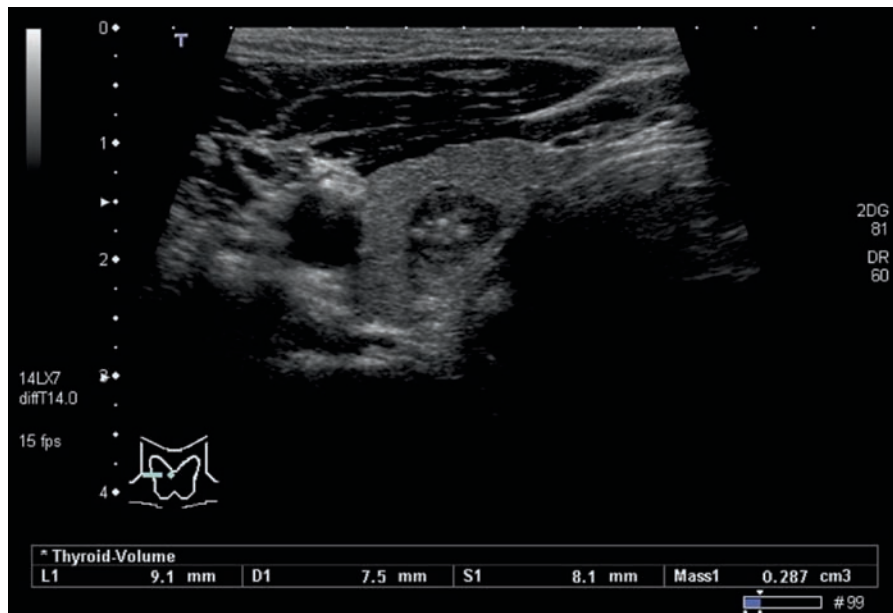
Ultrasonographic profiles of medullary thyroid carcinoma. This nodule shows a similar ultrasonographic profile of papillary carcinoma
